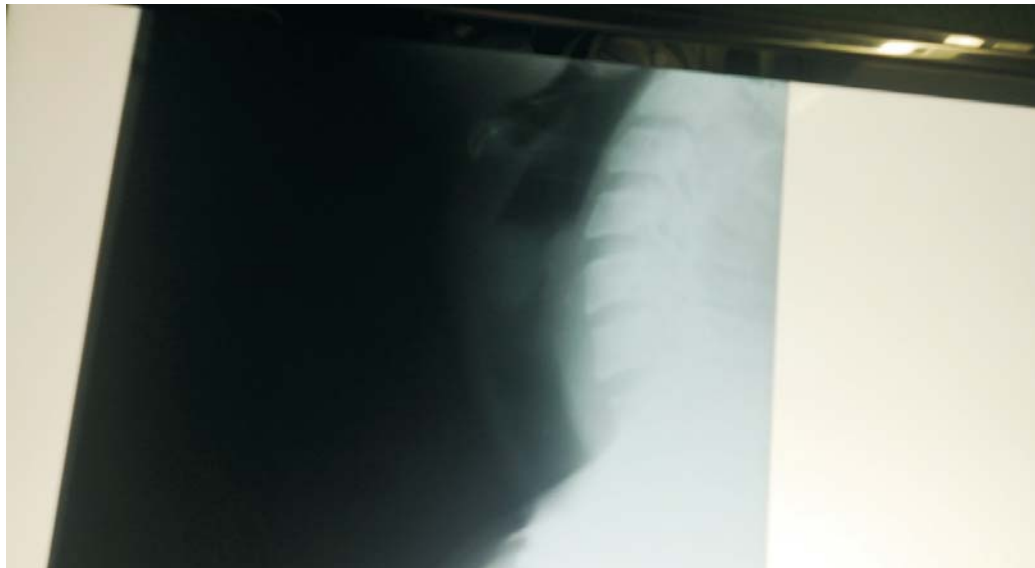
Lateral view soft tissue x-ray of neck showing a soft tissue mass at the laryngeal level with a slit of air column posteriorly.
